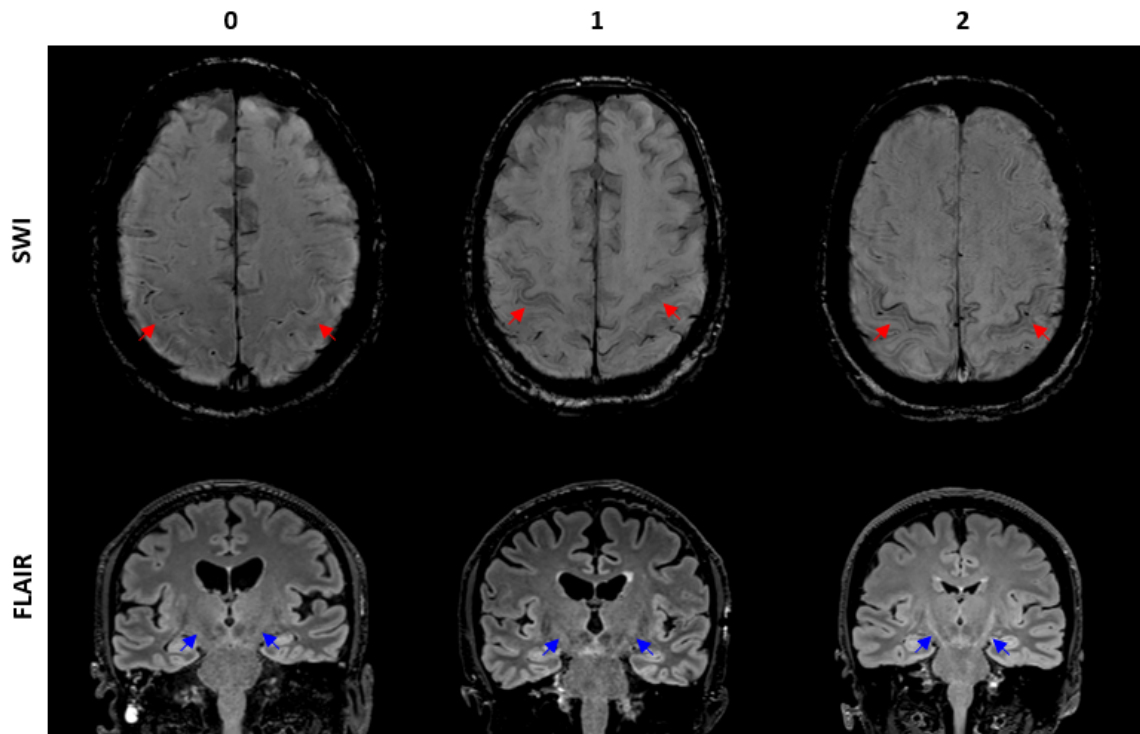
Examples of radiological signs in ALS patients: in the first row, SWI hypo-intensity in the precentral gyrus (“motor band sign”); in the second row, T<sub>2</sub>w FLAIR hyper-intensity in the cortico-spinal tract (protocol details are in Sec. 1.2.1). Radiological evaluation was performed using a 3-score ranking as suggested from previous studies<sup>(81)</sup>: 0 = absent (first column, M/64 years old), 1 = present, mild (second column, M/68 years old), 2 = present, marked (third column, F/55 years old) (IRCCS Istituto delle Scienze Neurologiche di Bologna, Functional and Molecular Neuroimaging Unit, IT)
